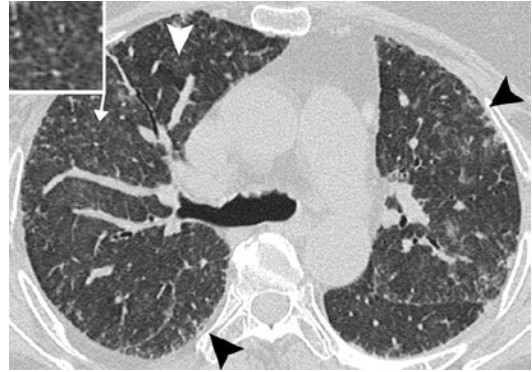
Chronic hypersensitivity pneumonitis in a 52-year-old man related to mold exposure. Axial CT image shows patchy ground-glass opacities with associated centrilobular nodules (inset: magnified view of centrilobular nodules). Also note mild subpleural reticular opacities (*black arrowheads*) indicating fibrosis, and suble mosaic attenuation (*white arrowhead*)
